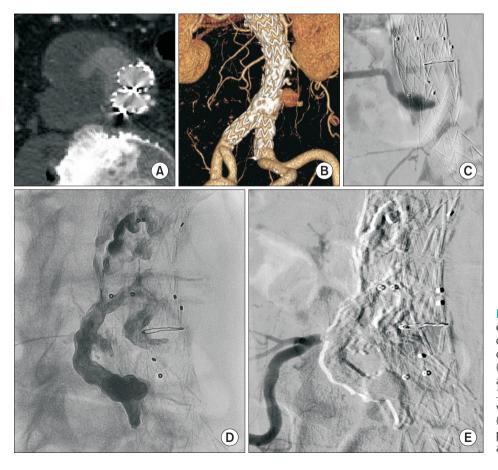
Endoleak of uncertain origin, type 3 cannot be ruled out, treated by complete filling of the sac lumen using Onyx (Medtronic). (A) CT angiography, axial view; (B) CT angiography, 3-dimmensional reconstruction view; (C) diagnostic angiography; (D) Onyx application, and (E) post-procedural completion angiography.
